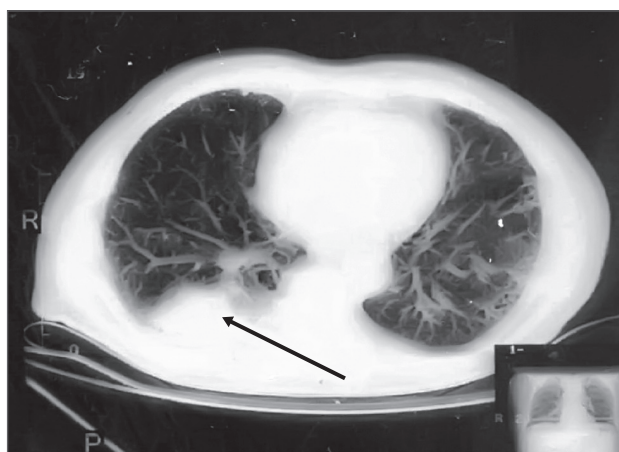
CT of the same patient where in the area of the right lower mediastinum a lesion with abnormal margins and little presence of pleural fluid is detected, probably due to inflammatory process (arrow).
